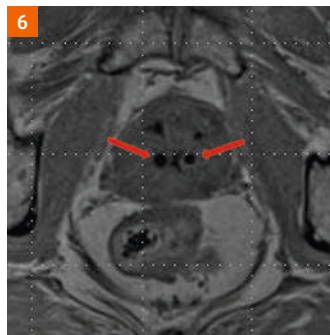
T1-weighted prostate 1.5T MRI from Gothenburg with Gold Anchor 0.40 mm x 20 mm.
